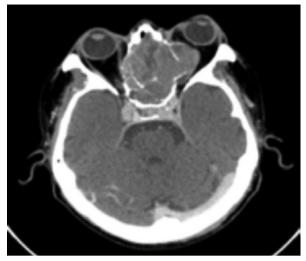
A CT scan showed a mass in the nasal cavity, extending to the left orbital cavity and causing marked proptosis of the left eye
